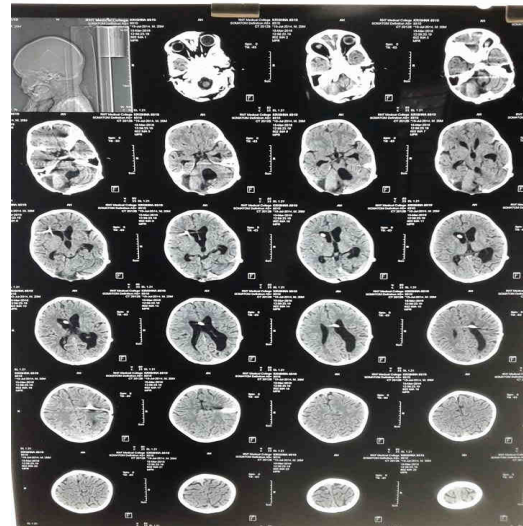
Follow up CT head showing postoperative hydrocephalus
